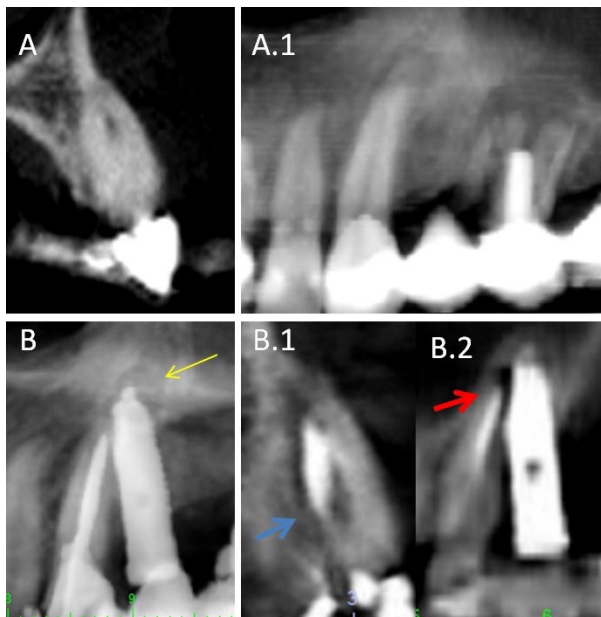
Case three: (A and A.1) before implant placement surgery of tooth 11, the periapical region of tooth 12 had no injury. (B) The apical region of the implant of tooth 24 (yellow arrow) is in contact with the apical region of tooth 23. (B.1) A cross-sectional image demonstrates the extent of the periapical lesion through the palatal wall of the root of tooth 23, and (B.2) in another panoramic section, the extent of the lesion between the implant contact area and the tooth area in the periapical region.
